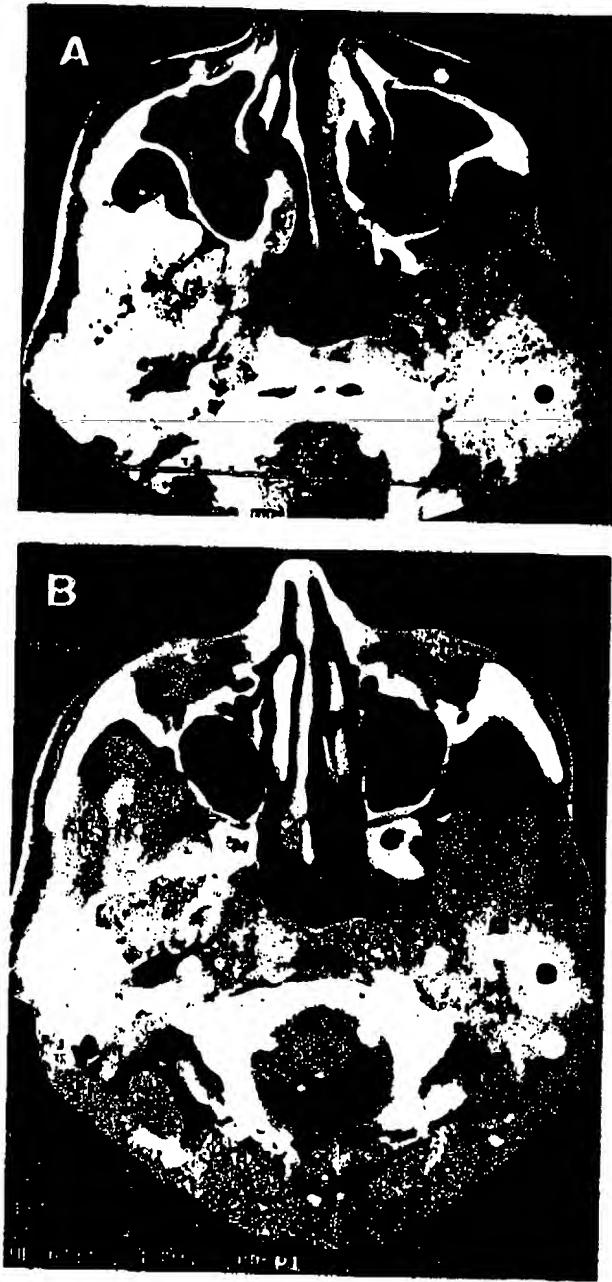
Axial post-contrast CT images (before and after 6 doses of 10^{10} pfu) in patient 23, with recurrent HNSCC and previous hemimandibulectomy and flap reconstruction. (A) Pretreatment, postoperative distortion and enhancing tumor in the left condylar fossa/subtemporal region (dot). (B) Posttreatment, > 50% tumor reduction (dot).
